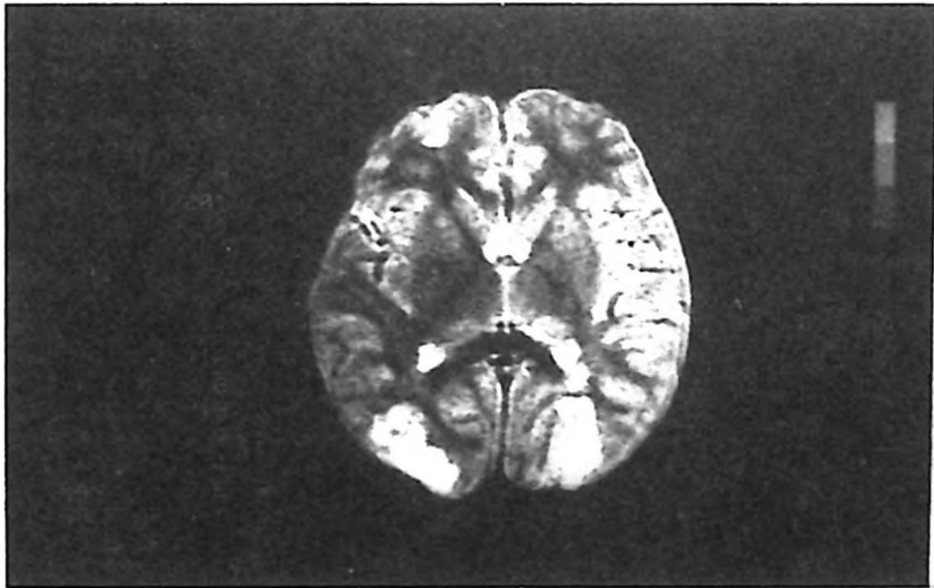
Bilateral cortical and subcortical areas of increased density on cerebral magnetic resonance imaging (MRI).
